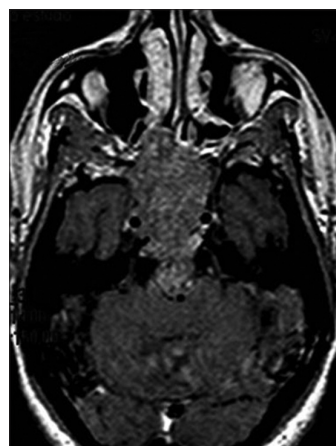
T1 postcontrast MRI imaging showing sphenoid sinus invasion
